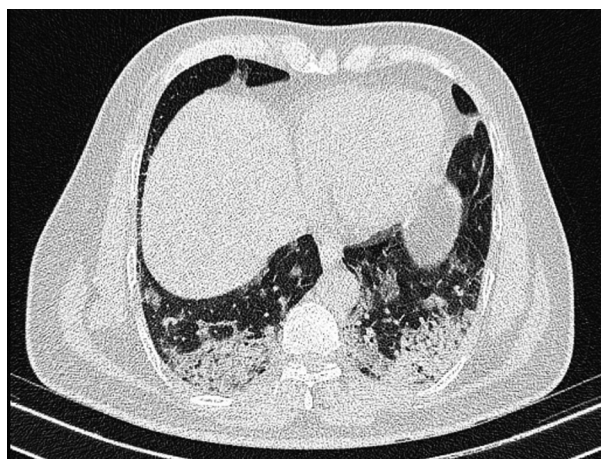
Figure/table-8: Axial HRCT chest image shows reticular opacities with bronchiectatic changes
